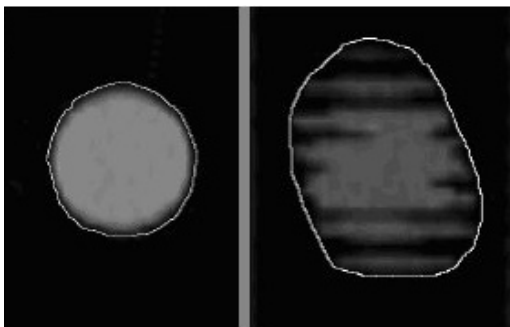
Coronal section of a 2 cm target depicting volume aliasing of the image on the left during pretreatment CT imaging in the presence of motion.
